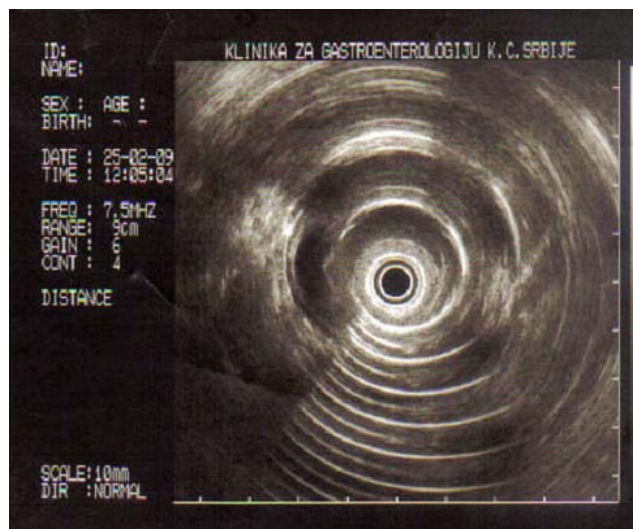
Endoscopic echosonography revealed the intramural, extramucous change of 25 × 15 mm in size on the gastric antrum posterior wall
